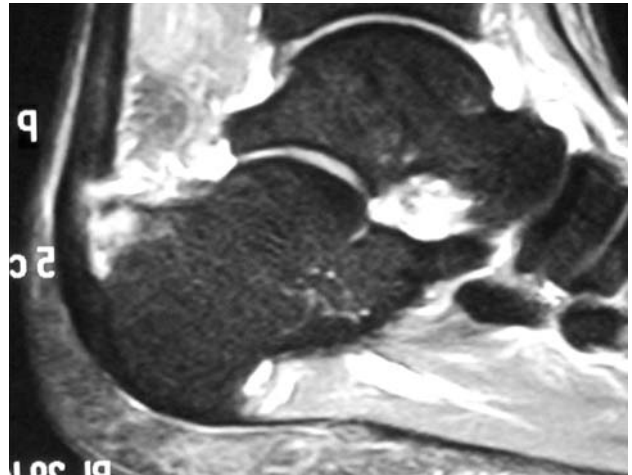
Preoperative MR image.
